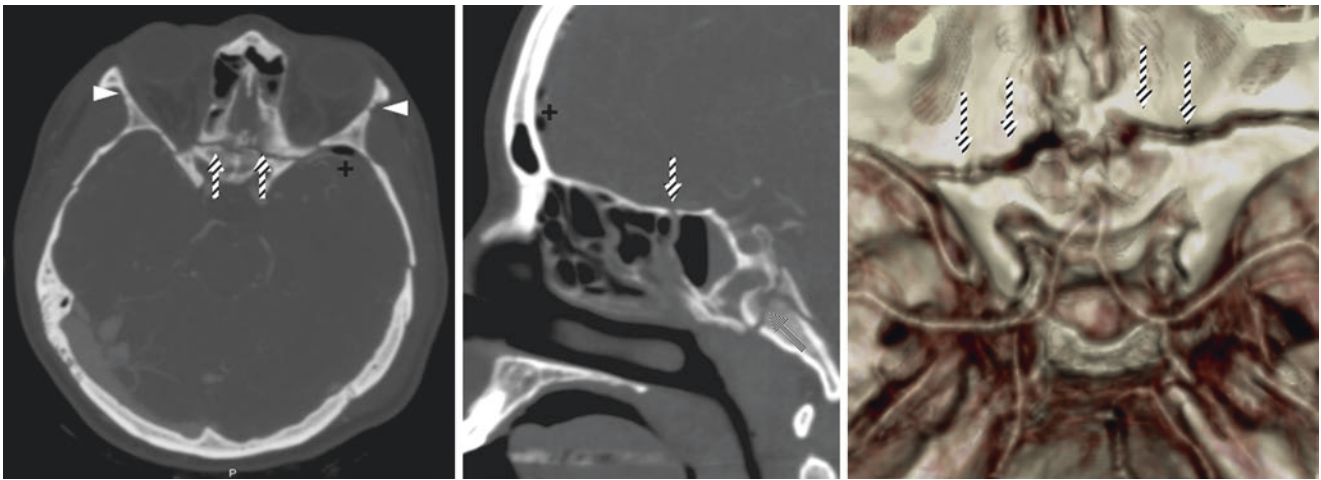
Comparison case: A 23 year old with trauma, with axial (*left*) and sagittal (*middle*) reformats from a CTA. Note normal, incompletely fused zygomaticofrontal sutures bilaterally (*arrowheads*) but with a diastatic fracture line crossing the midline (*zebra arrows*) along the sphenoethmoidal suture. Note also how the fracture lines often
